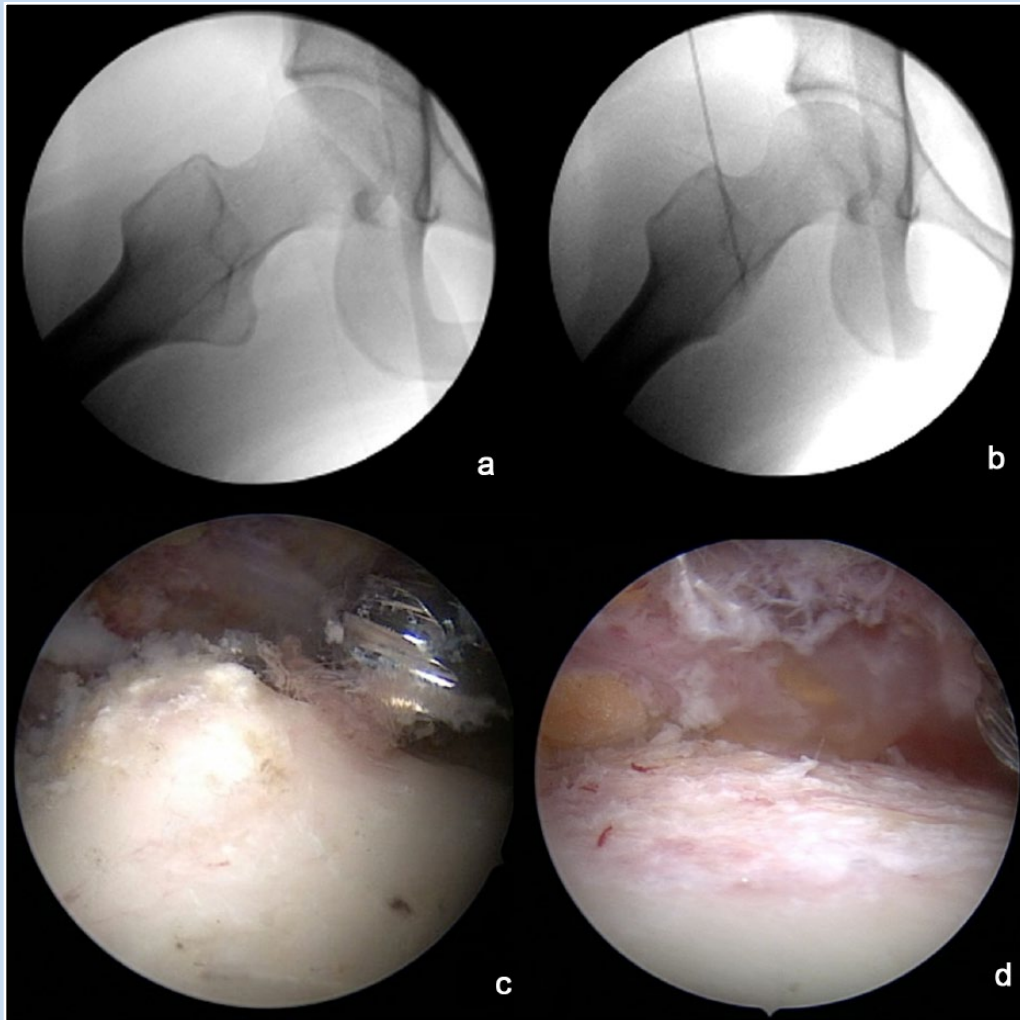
(a) Intraoperative fluoroscopic radiograph profiling the lesser trochanter. (b) Lesser trochanter resection has been performed for ischiofemoral impingement. (c) Arthroscopic visualization of the lesser trochanter through the distal anterolateral portal. (d) Visualization after resection of the lesser trochanter.
